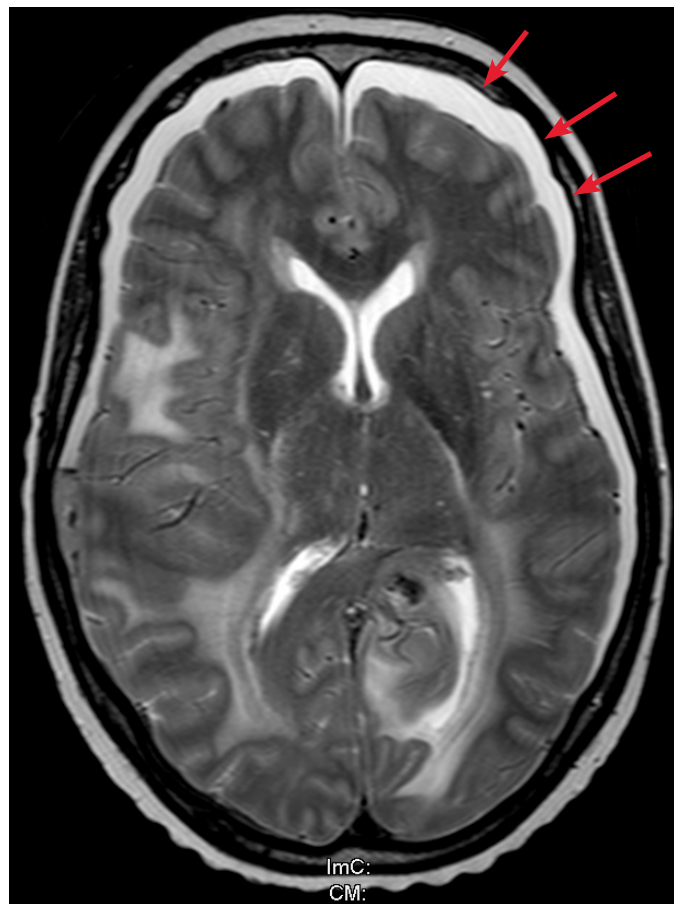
MRI image (T2W) showing hygroma development (arrows) following high-dose pulsed erlotinib. MRI: magnetic resonance imaging.
